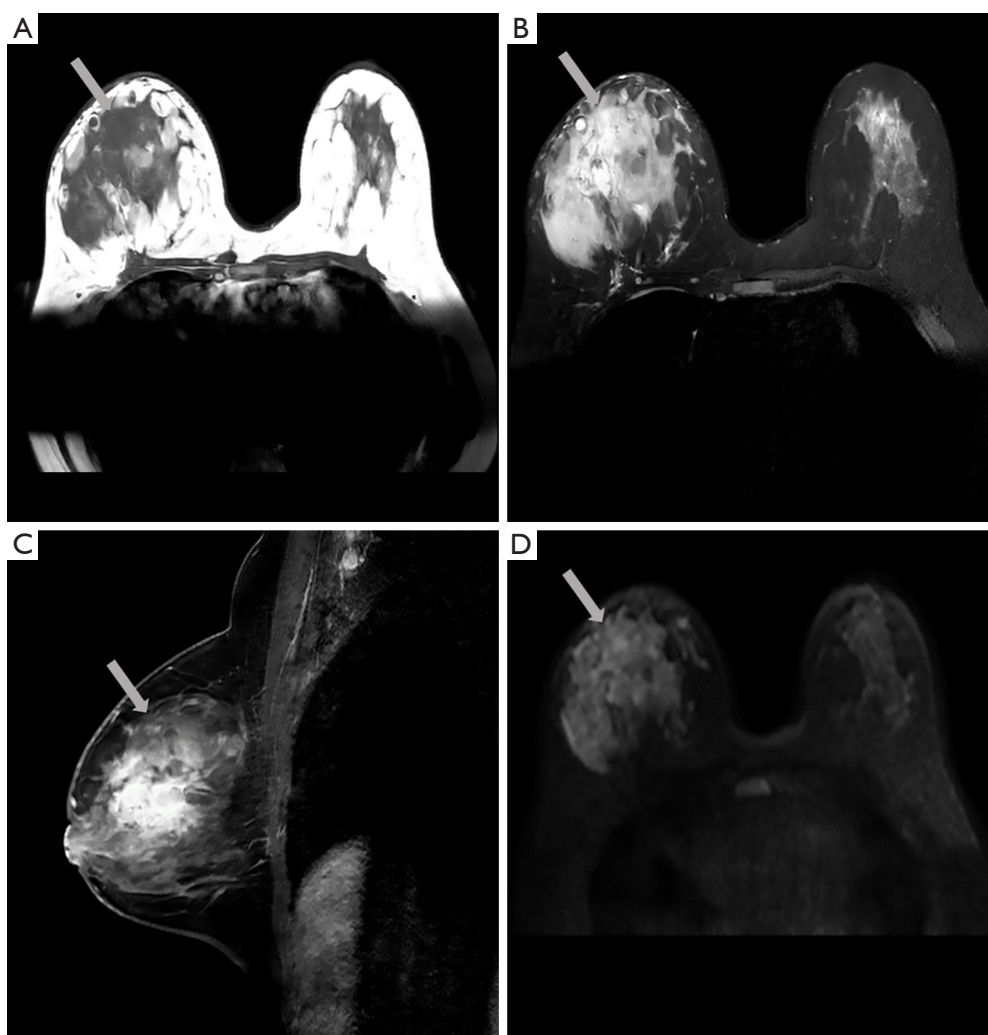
MRI of the giant breast angiosarcoma (arrow). (A) Axial T1W image shows a large, irregular hypointense mass in the right breast (TR =571.96 ms; TE =8.04 ms). (B) Axial T2W MRI with fat saturation shows a heterogeneous hyperintense mass in the right breast (TR =4,428.30 ms; TE =70.00 ms). (C) Sagittal dynamic contrast-enhanced MRI in early phase shows a heterogeneously enhanced and diffusely distributed mass in the right breast (TR =5.51 ms; TE =2.80 ms). (D) Axial DWI shows a hyperintensity mass in the right breast (TR =9,000.00 ms; TE =52.35 ms; B value =800). MRI, magnetic resonance imaging; T1W, T1-weighted; TR, repetition time; TE, echo time; T2W, T2-weighted; DWI, diffusion-weighted imaging.
